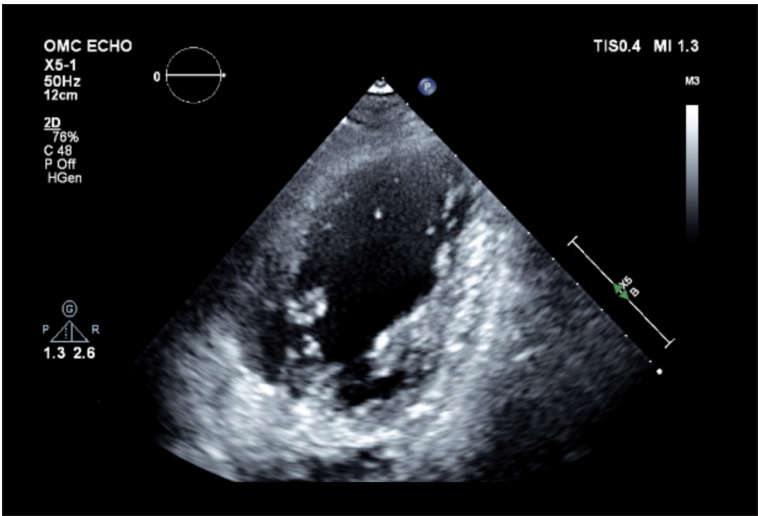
2D echocardiogram demonstrated severe hypokinesis of the proximal 2/3 of the septal wall anterior lateral and posterior with apical sparing consistent with reverse takotsubo cardiomyopathy and new left ventricle ejection fraction of 40%.
